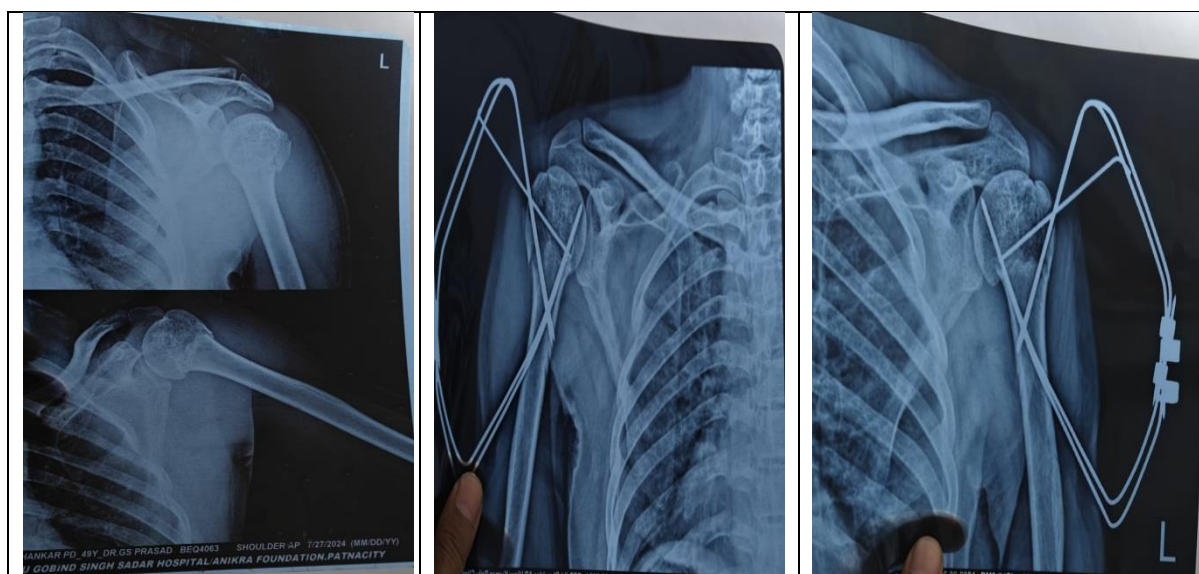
Pre- and post-operative radiographs showing proximal humerus fracture and fixation with modified tensioned wire technique.
